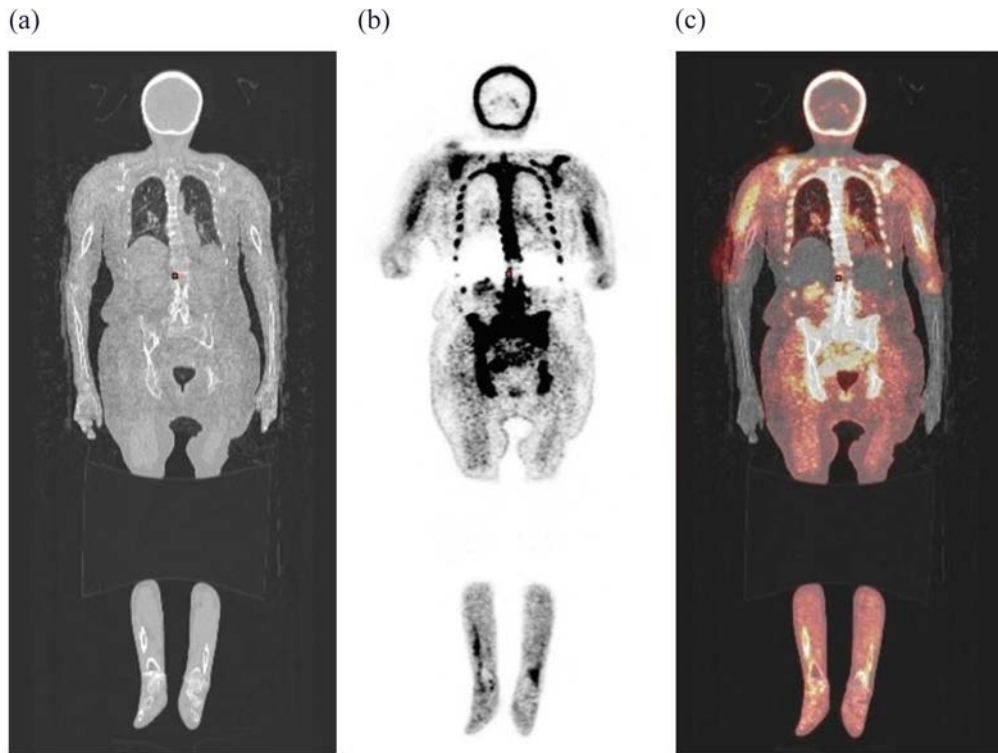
Coronal CT (a), AC-PET (b) and fused AC-PET/CT (c) images of a whole body FDG-PET/CT study demonstrating artefacts from intra-scan motion of the arms. It should be noted that the patient moved her arms between the CT and PET data acquisition. AC: attenuation corrected.
